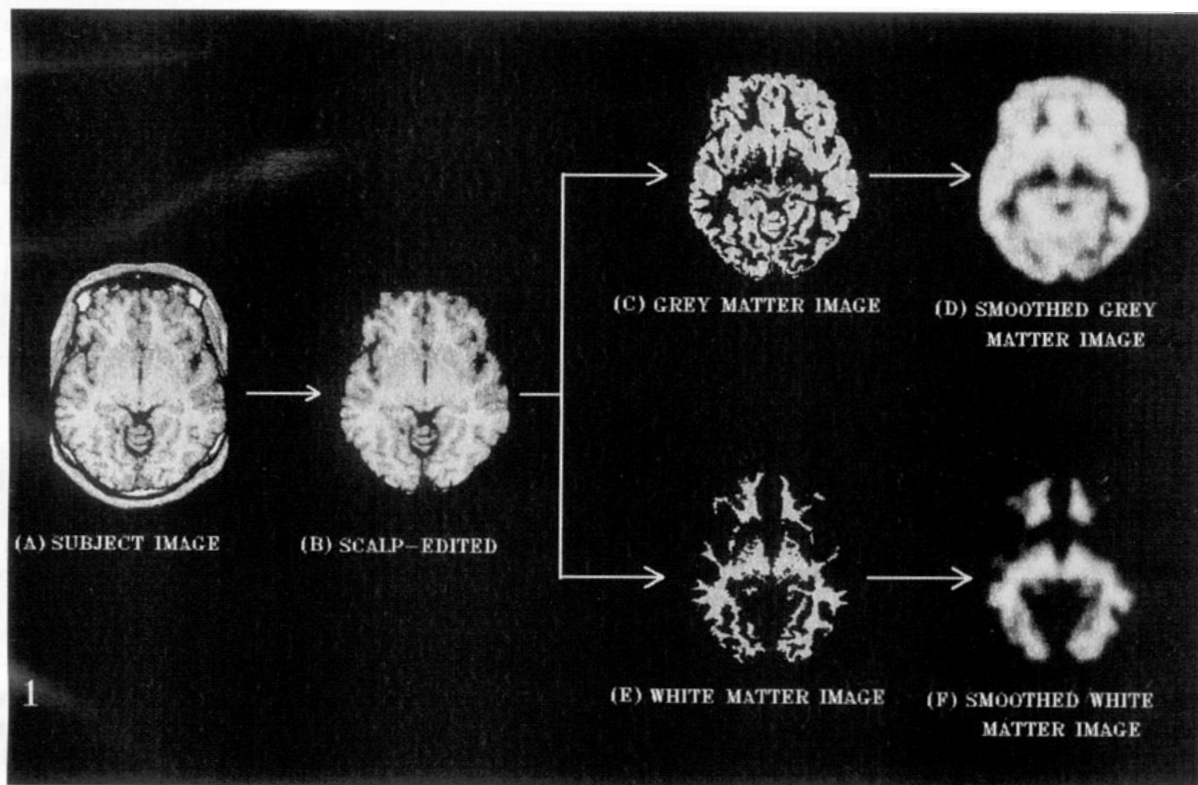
Processing of structural MRI scans. The brain is reoriented to the intercommissural (AC-PC) plane (A) and then scalp-edited by the automatic scalp-editing program ATOMIA with final completion performed manually (B). The gray matter image is produced by segmentation between the gray-CSF and gray-white thresholds and setting pixels within this range to an arbitrary intensity value (C). The gray matter image is smoothed using an 8-mm FWHM (full width half maximum) isotropic Gaussian kernel (D). The white matter image is produced by segmentation above the gray-white threshold and setting pixels within this range to an arbitrary intensity value (E). The white matter image is smoothed using an 8-mm FWHM (full width half maximum) isotropic Gaussian kernel (F).
